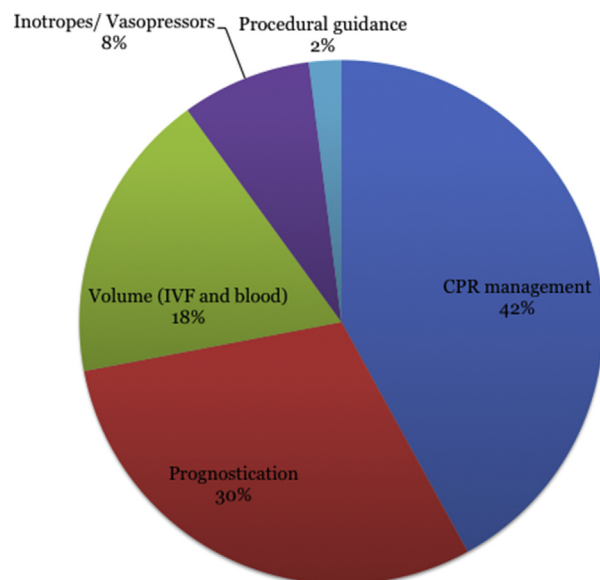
Breakdown of the management changes made in 67% of cases in response to transesophageal echocardiography findings. CPR = cardiopulmonary resuscitation; IVF = intravenous fluids.
